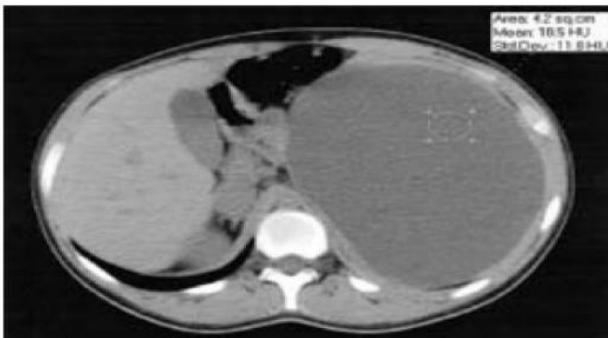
Axial section of an abdominal CT without injection, showing a voluminous intrasplenic mass, homogeneous, of liquid density.
